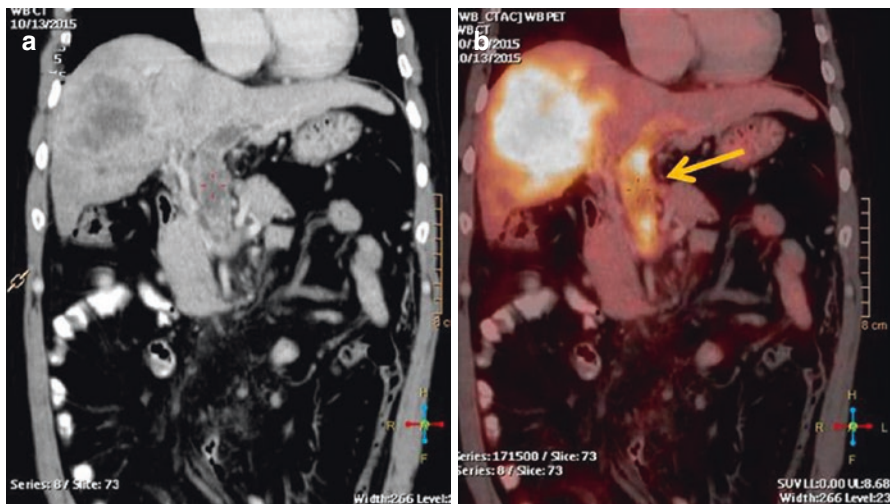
Patient with HCC involving the right lobe of the liver as seen by the irregular hypodense lesion on the coronal section of CECT images (a) involving seg IV/VIII/VII and V and presence of right portal vein (PV) thrombosis, extending to MPV and SMV. FDG PET/CT done for staging shows intense FDG uptake in the primary mass (b) involving the lesion in right lobe of the liver with linear uptake (arrow) correlating with the tumor thrombus in the portal vein
